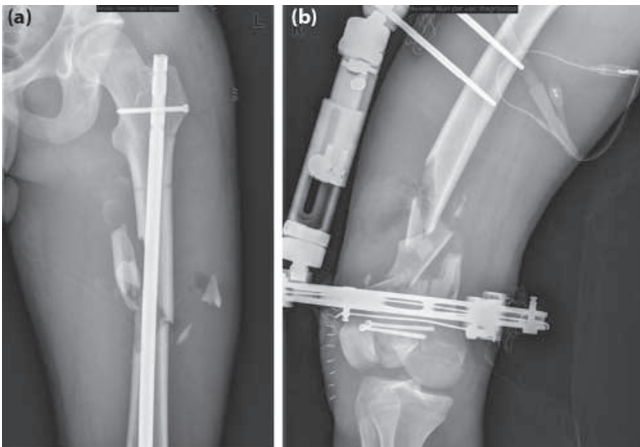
a) AP radiograph left femur and b) lateral radiograph right femur after the second procedure.
